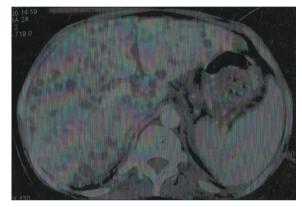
Computed tomography scan showing liver abscesses
